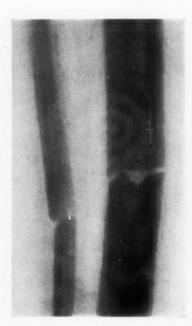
Case I. X-ray two weeks after operation.
